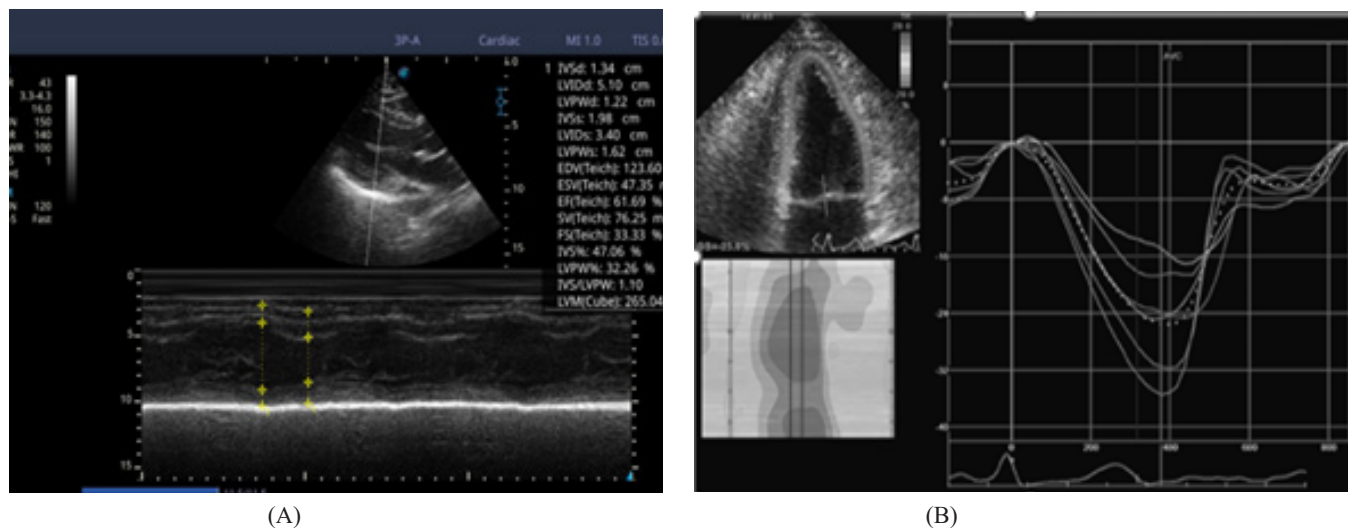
(A) regular transthoracic echo left ventricular end-diastolic dimension, left ventricular end-systolic dimension and ejection fraction and (B) speckle Tracking longitudinal global strain.
